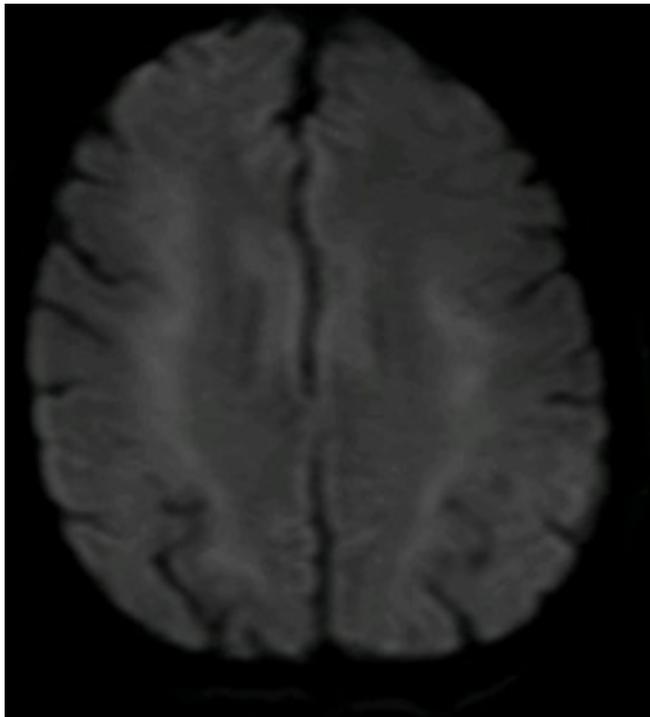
MRI brain, diffusion weighted imaging axial section showing hyperintense signals in bilateral deep white matter.
